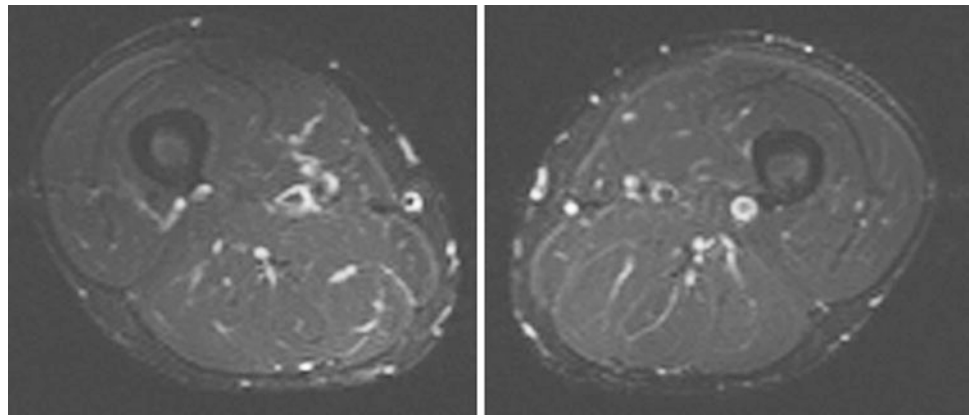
Normal MRI of muscle (same subject as in Fig. 1.4). Axial STIR MRI of the bilateral thighs demonstrates no evidence of edema-like changes (images courtesy of Prof. Dr. M. A. Weber, Heidelberg)
